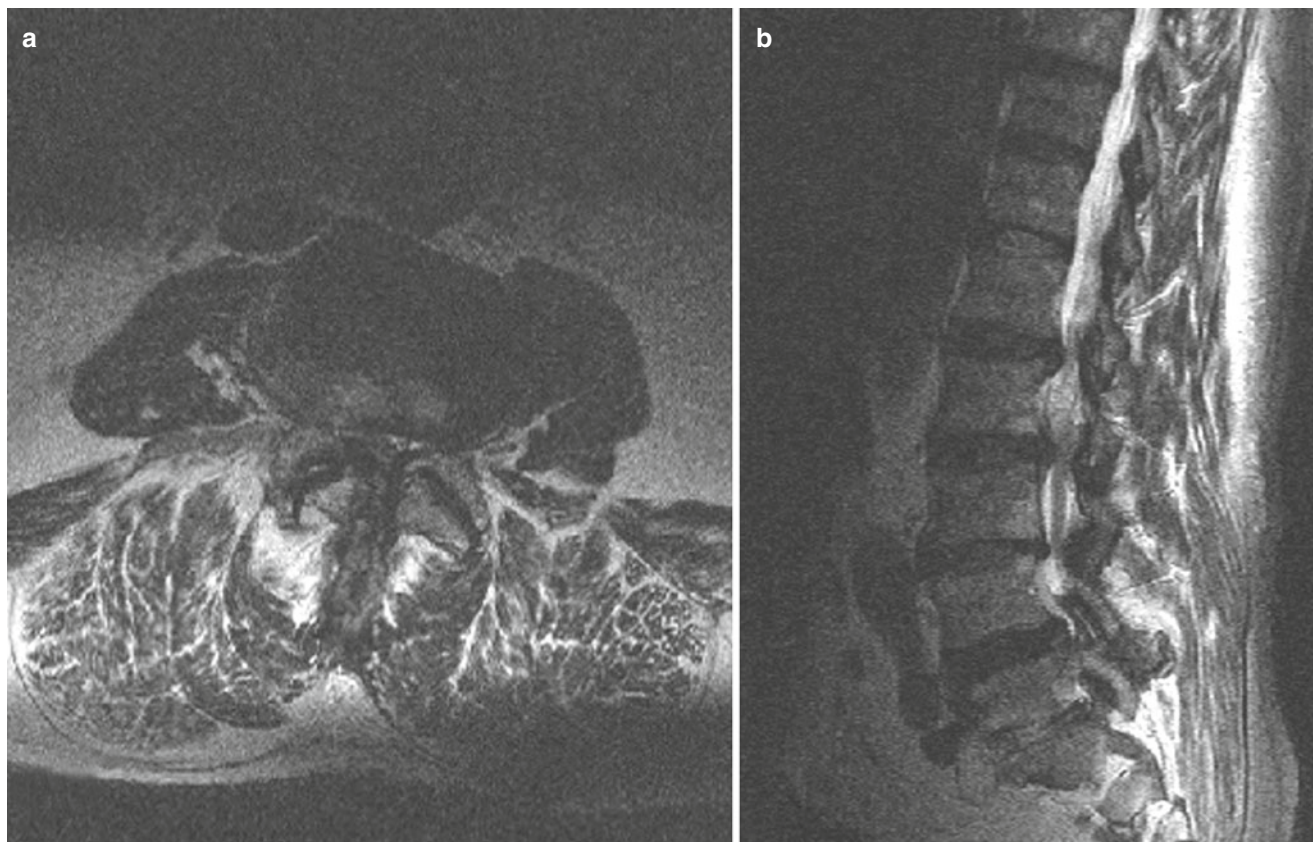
MRI showing lumbar vertebral stenosis: note the disappearance of the spinal fluid in T2-weighted images (a). Lateral view shows multiple sites with narrowing of the spinal canal (b)
